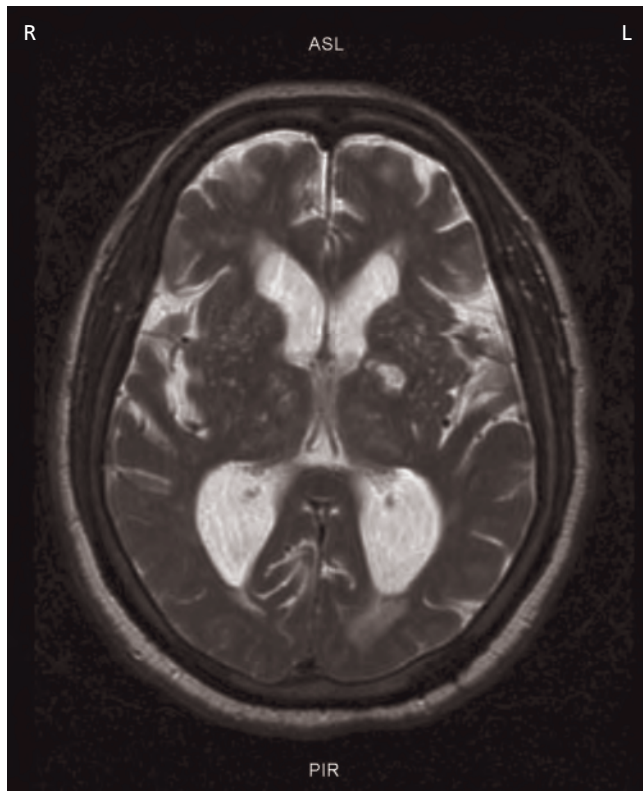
Diffuse small vessel disease (MRI T2W).
